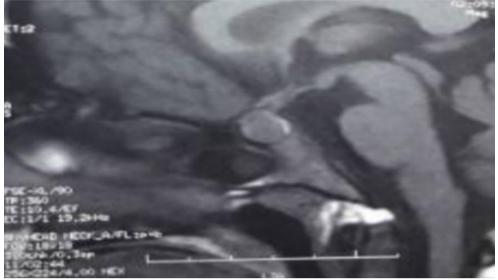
Sagittal MRI showing ischemic lesions in pituitary gland.
